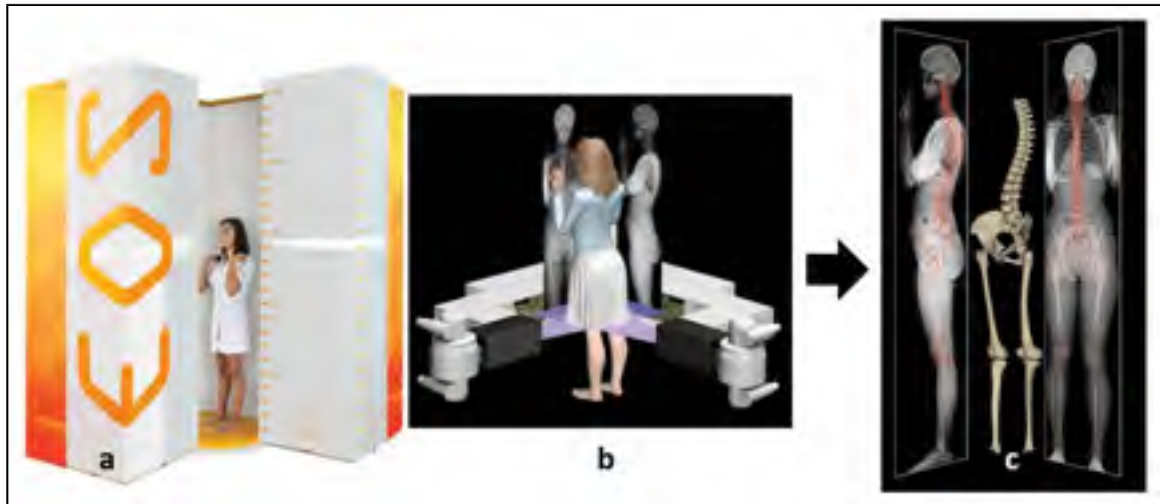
EOS® low-dose imaging system and the reconstruction of the 3D geometry of the bones using a pair of biplane X-ray images. Adopted from <http://www.eos-imaging.com>, 2016
